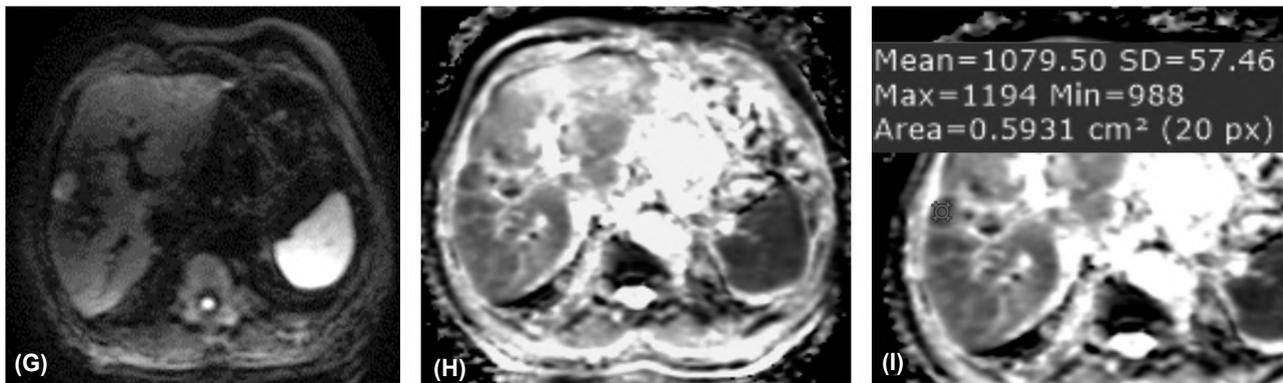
A 70-year-old male patient with chronic viral hepatitis C with elevated AFP (1000), diagnosed as HCC involving right hepatic lobe segment V underwent TACE ablation with reduced AFP (200), followed up by DCE MRI with DWI for assessment of treatment response after 1 and 3 months following chemo-embolization showed tumoral non-viability. (From “a” to “i” images) 1<sup>st</sup> follow-up post-treatment DCE MRI with DWI. (A, B) Axial T2 & T1 WIs images revealed heterogeneous signals (predominantly bright in T2 and iso-intense in T1 with hyper-intense and hypo-intense foci seen within of the chemo-embolized segment V treated lesion. (C, D) Axial T1 LAVA pre-contrast & late arterial phase images show small non-rim APHE in the posterior portion of the treated focal lesion. (E, F) Porto-venous & delayed phases of T1 LAVA images show small area of progressive enhancement along the postero-medial portion of the treated hepatic focal lesion representing granulation tissue (expected post TACE response). (G, H, I) DWI (b-value 800) and corresponding ADC map images show restricted diffusion<sub>3</sub> manifested by bright signals in DWI and corresponding dark signals in ADC mapping series with ADC value =  $1.07 \times 10^{-3} \text{ s/mm}^2$ . Diagnosis: Well ablated H.C.C.
